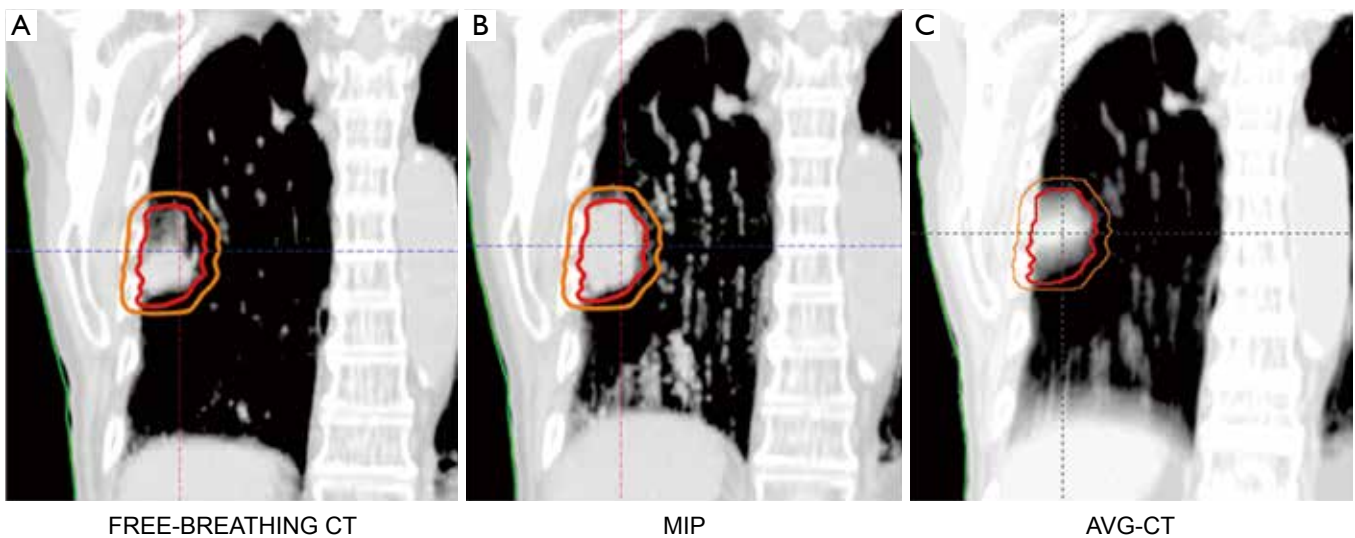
(A) Positional differences between the tumor position on the free-breathing CT; (B) maximum intensity projection (MIP); and (C) AVG-CT, indicating that the FBCT was acquired at an extreme phase of the breathing cycle. Contours show the ITV and PTV. Abbreviations: AVG-CT, average computed tomography; ITV, internal target volume; PTV, planning target volume.
